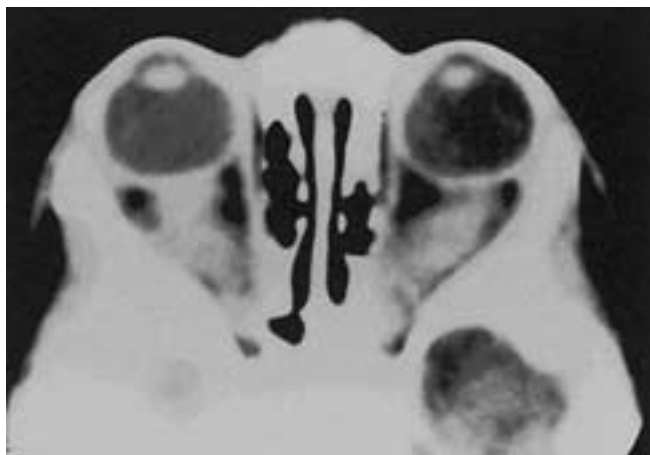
Bilateral optic gliomas with neurofibromatosis. Axial contrast CT scan shows bilateral enlargement and enhancement of optic nerve gliomas.
